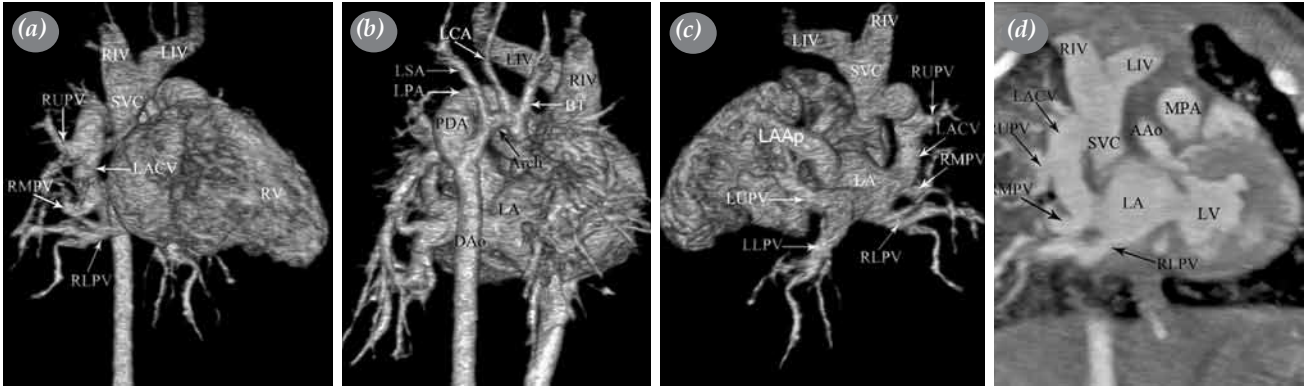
(a) Anterior, (b) posterior and (c) oblique posterior (d) volume rendering and coronal multiplanar re-formatted multi-slice computed tomography angiography images showing a right-sided levoatriocardinal vein connecting the superior vena cava and the left atrium via the right middle pulmonary vein. The right upper pulmonary vein abnormally drains into the levoatriocardinal vein. Hypoplastic ascending aorta and aortic arch and large patent ductus arteriosus between the left pulmonary artery and descending aorta are also shown.
